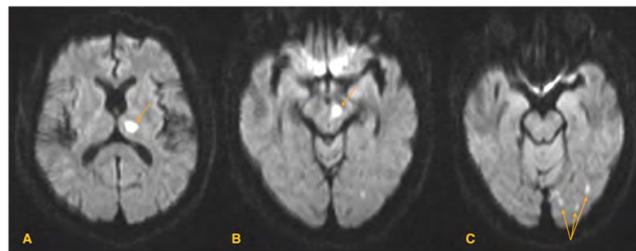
Diffusion-Weighted Magnetic Resonance Imaging (DWI-MR) of the brain shows infarcts (arrowheads) involving left thalamus (A), left midbrain (B) and left occipital lobe (C).
